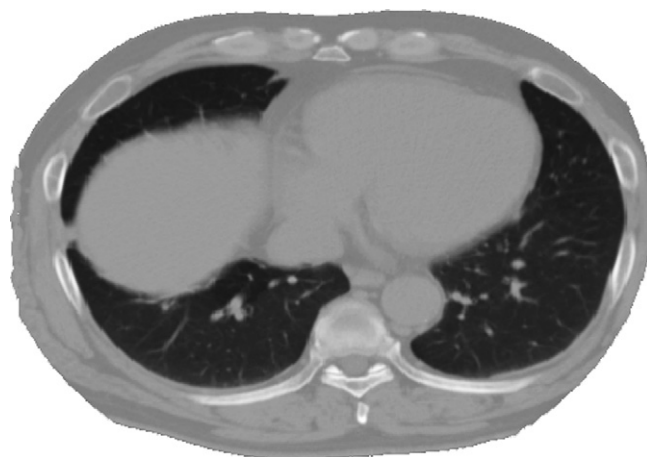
CT scan layer of an abdominal part of the human body (size: 512×512).
